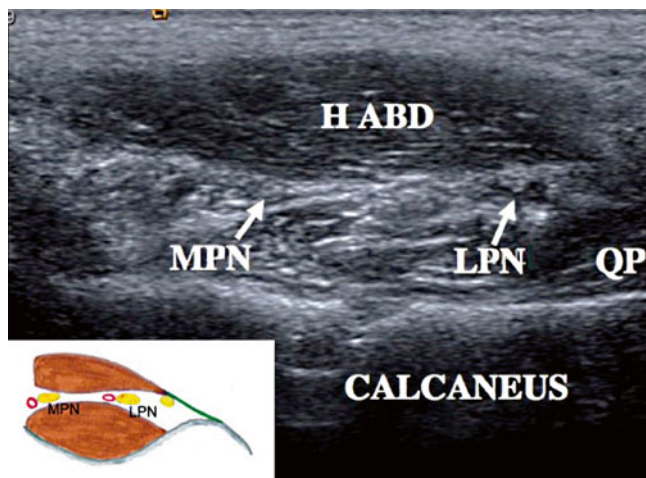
Ultrasound anatomy of the distal tarsal tunnel, axial scan. *LPN* lateral plantar nerve, *MPN* medial plantar nerve, *QP* quadratus plantae muscle, *H ABD* abductor hallucis muscle (From Fantino [54]. Reprinted with permission from Springer)
